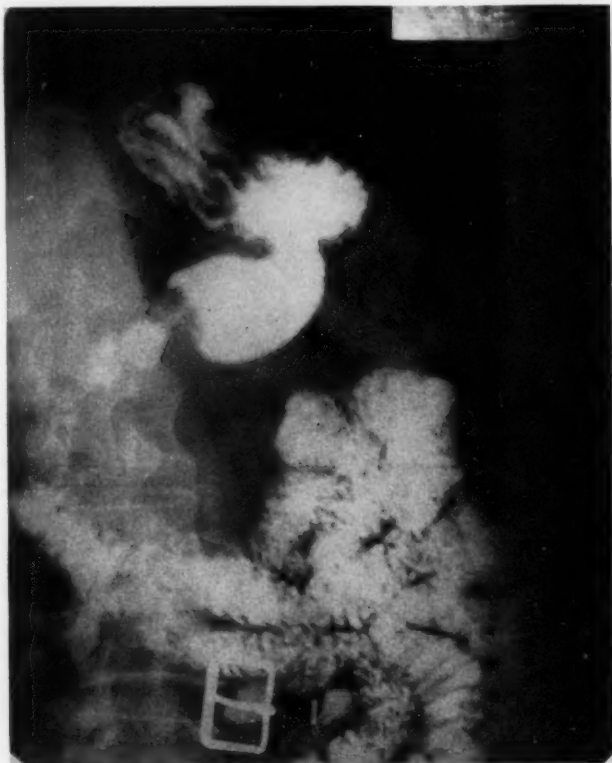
Case 4. Oblique view of diaphragmatic herniation. The striations of the barium-coated stomach rugae are clearly seen above the level of the diaphragm. The esophagus and the esophagogastric junction show poorly in this film. The lower borders of the esophagus have, therefore, been outlined with ink for greater clarity. The Roentgenologist thought this was probably a herniation with a congenitally short esophagus.
